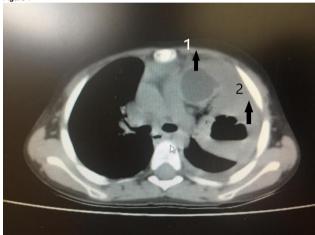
CT image showing the cardiac hydatid cyst (1), and the pulmonary hydatid cyst (2).
